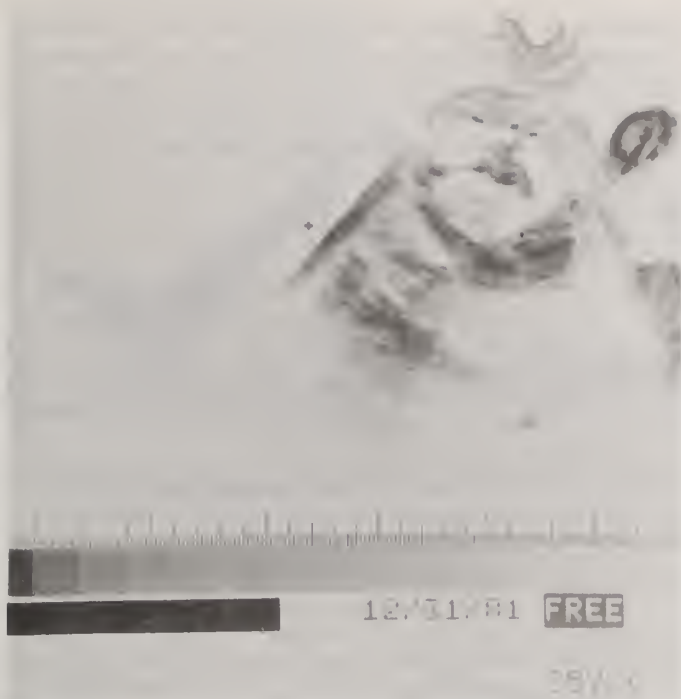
Transverse sonographic section of the fetal abdomen.
